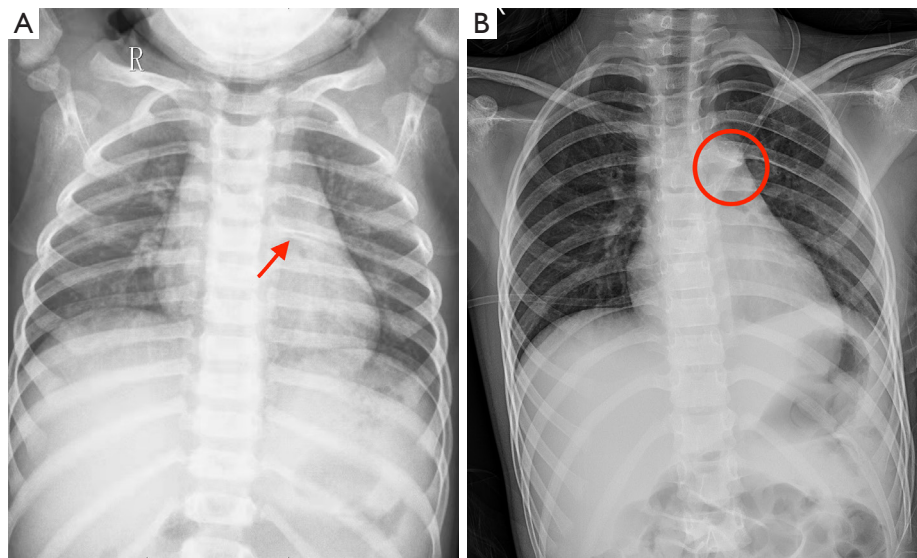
Chest image of intrathoracic rib. (A) The red arrow on the chest X-ray shows the intrathoracic rib at 2 years old. (B) A bedside X-ray on the first postoperative day showed the broken end of the intrathoracic rib as indicated by the red circle.
